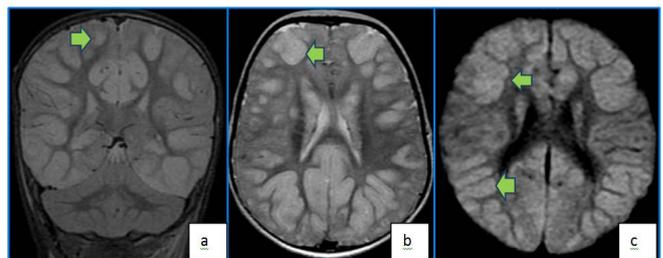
Coronal T2 FLAIR (a) and Axial T2 (b) Images Demonstrate Diffuse High FLAIR And T2 Signal in Bilateral Cortices from Edema. Axial DWI Image (c) Demonstrates Cortical High DWI Signal Indicative of Edematous and Ischemic Changes as Well in a Patient with Post Traumatic Hypoxic Injury
